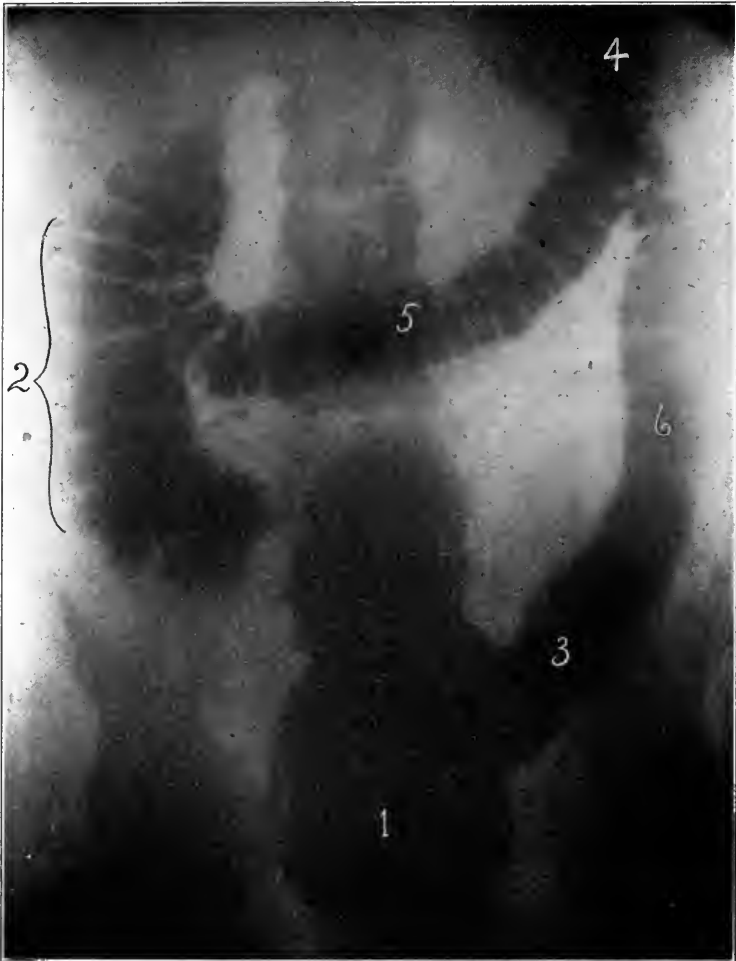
Fairly normally festooned colon outlined by bismuth enema, patient prone. The numbers indicating graphically the varying sites of carcinomata of the large intestine in the order of frequency of occurrence. (Note radiographic demonstration of marked stricture of appendix.)
